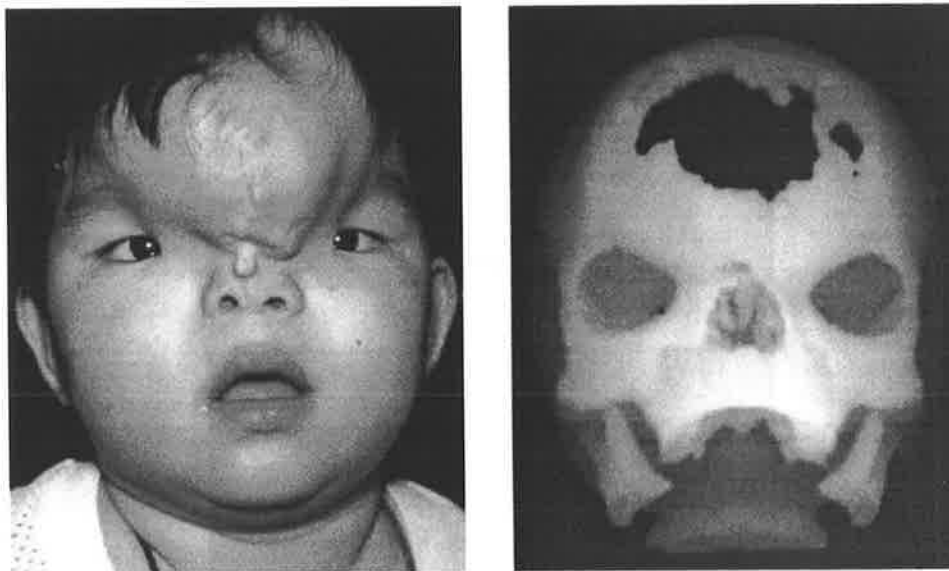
A. A meningoencephalocele associated with a severe midline craniofacial cleft. B. The bony defect is seen in a three-dimensional CT reconstruction.
